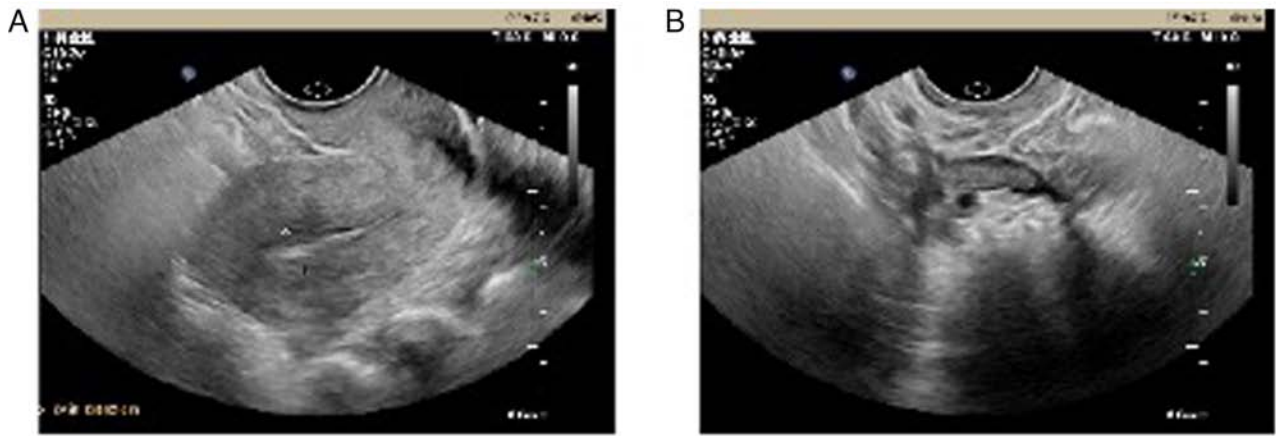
Normal ultrasonography of the pelvis of a 21-year-old woman with pulmonary embolism caused by choriocarcinoma. (A) No obvious echo found in the uterine cavity. (B) No obvious echo found in the ovary.
